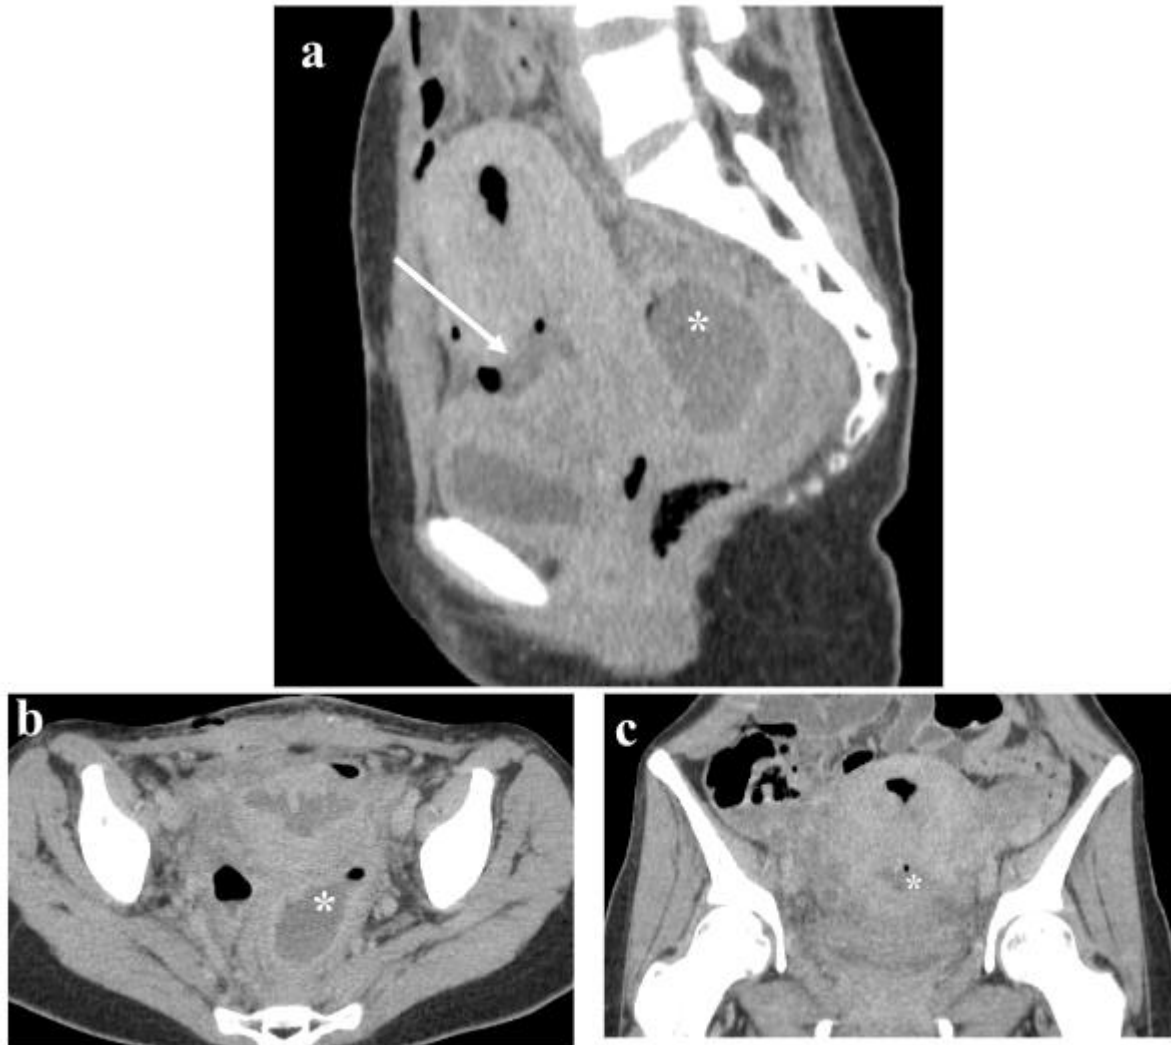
contrast-enhanced CT scan of the pelvis on sagittal (a), axial (b) and coronal (c) views, reveals a disruption of the uterine wall continuity (as indicated by the white arrow) with adjacent collections containing air bubbles (*)
